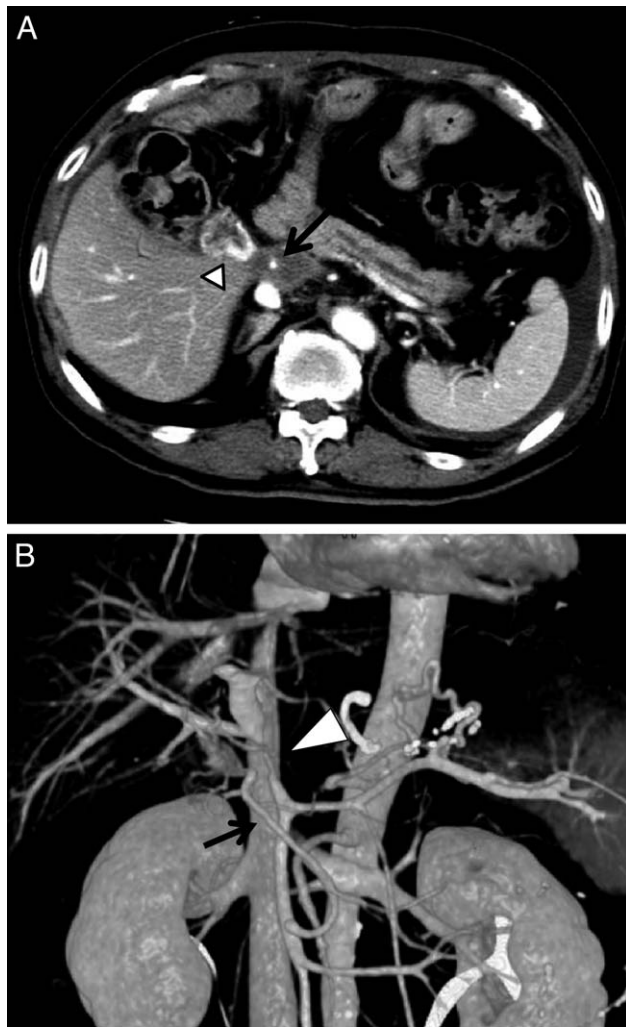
(A) Abdominal-enhanced CT revealed severe stenosis (arrow) of the portal vein and intensive enhanced jejunal wall (arrowhead) at the choledochojejunosomy. (B) 3D-CT angiography also revealed portal stenosis (arrowhead) and a dilated jejunal vein (arrow).
